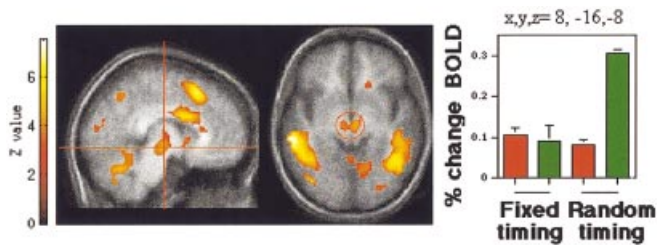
(Left) Substantia nigra activation found in the task-switching condition with unpredictable task order and random timing relative to baseline superimposed on a normalized axial MRI slice averaged across subjects. (Right) Percentage of signal change relative to baseline for each task-switching condition. Error bars indicate SEM.
